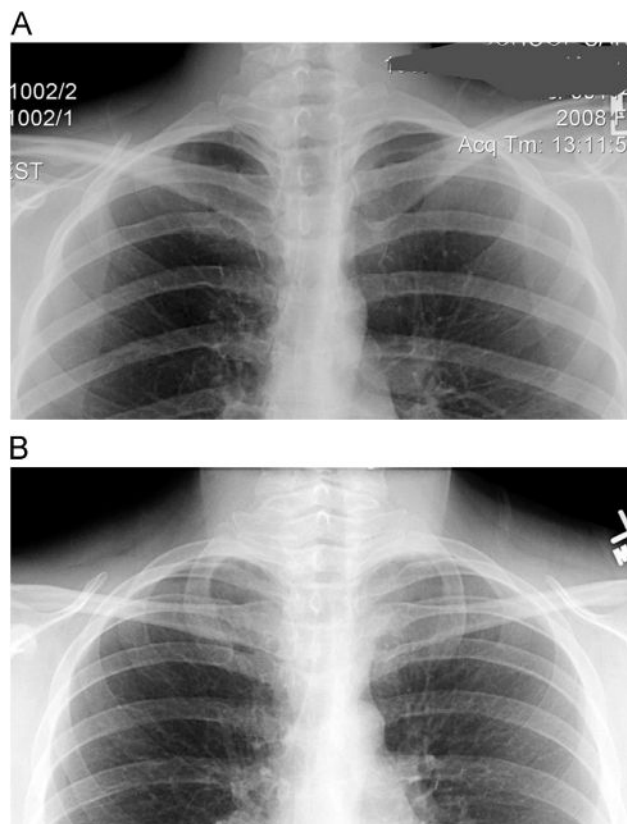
X-ray of first rib helps decide whether or not to remove rib. (A) Curved first rib can usually be left in place. (B) Straight first rib usually requires excision.
